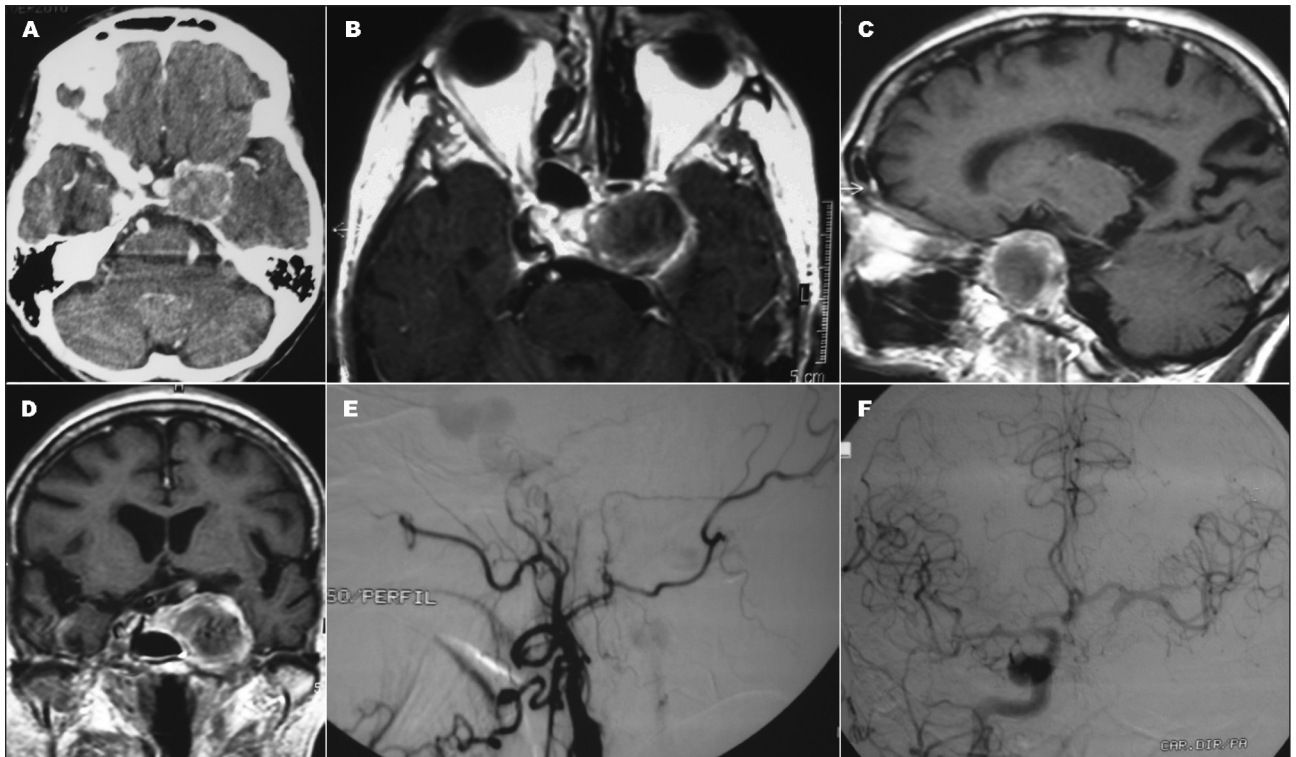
[A] CT scan showing giant aneurysm of left ICA, partially occluded by thrombosis and with bone erosion in a female 84-year-old patient with headache, retro bulbar pain, full III cranial nerve, left IV, VI, VI and V2. [B, C and D] MRI scan showing important dilatation of a partially occluded aneurysm with thromboses. E and F: Angiography showing left ICA spontaneous thrombosis with a patent collateral circulation.
